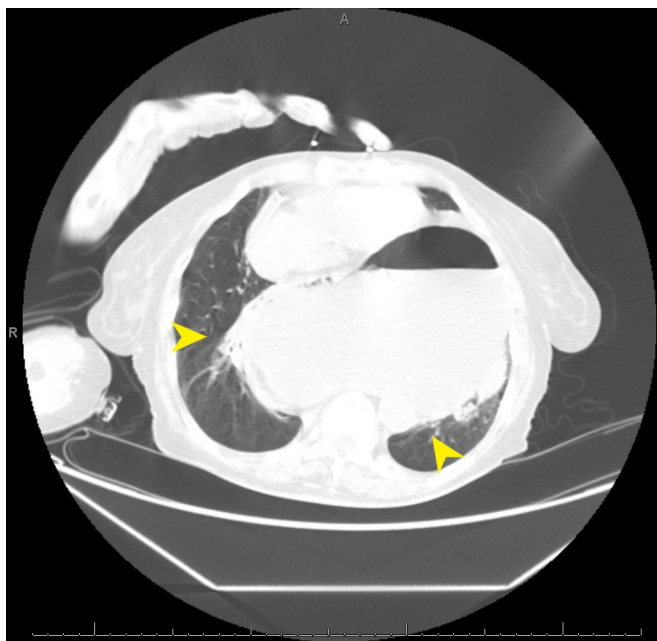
CT abdomen reveals herniation of the stomach into the posterior mediastinum (arrows), oesophageal dilatation, and gastric distension.
